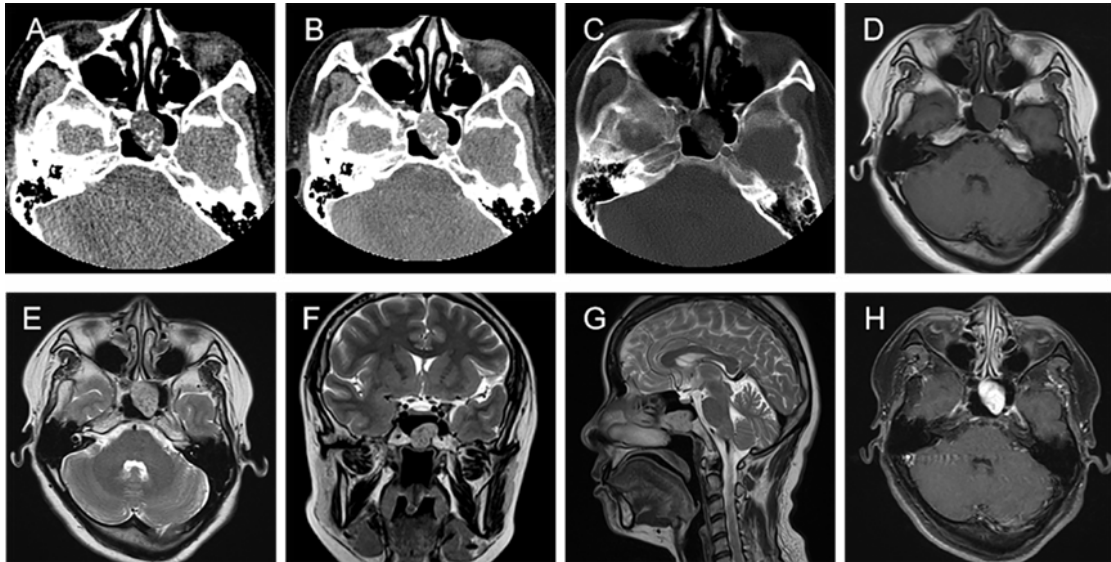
37-year-old female with left sphenoid sinus extraskelletal myxoid chondrosarcoma. A: Non-contrast CT (soft tissue window): Hypodense mass with multiple linear and granular calcifications. B: Contrast-enhanced CT: Marked homogeneous enhancement of the tumor. C: Non-contrast CT (bone window): Osseous destruction of clivus and left carotid canal. D: T1-weighted axial image: Isointense mass. E-G: T2-weighted axial, coronal, and sagittal images: Heterogeneous hyperintensity with punctate hypointense foci. H: T1-weighted enhanced axial image: Strong homogeneous enhancement. TECHNIQUE: Axial CT, 300 mAs, 120 kV, 2.5 mm slice thickness, 80 mL iopromide (Ultravist) contrast material; MRI using a 1.5 T Siemens Amira system included axial T1-weighted, axial, coronal, and sagittal T2-weighted, and axial post-contrast T1-weighted sequences, TR/TE 600/15 ms (T1), 5000/100 ms (T2), slice thickness 4 mm, field of view 240 × 240 mm, matrix 320 × 256.
